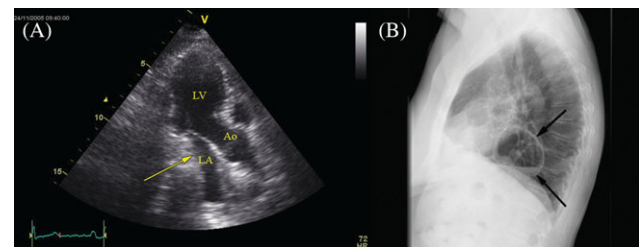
Transthoracic echocardiography analysis (A) in a patient with postprandial dyspnoea complaints revealed an impression of the left atrium (arrow). LA, left atrium; LV, left ventricle, Ao, aorta. Chest X-ray (B) shows an intrathoracic lying stomach appearing as a retrocardiac mass (arrows) with air and a fluid level.
